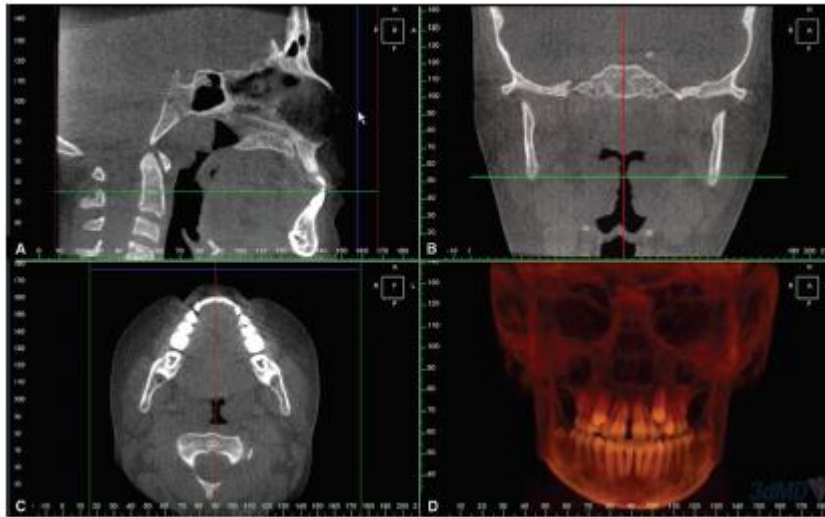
Orthographic projection view of CBCT analysis.(www.InTechOpen.com)
